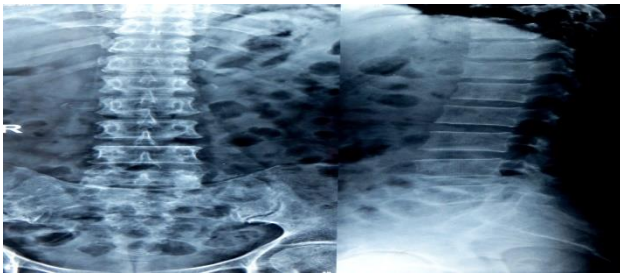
Radiograph of the lumbo-sacral region showing minimal information about sacral pathology.
